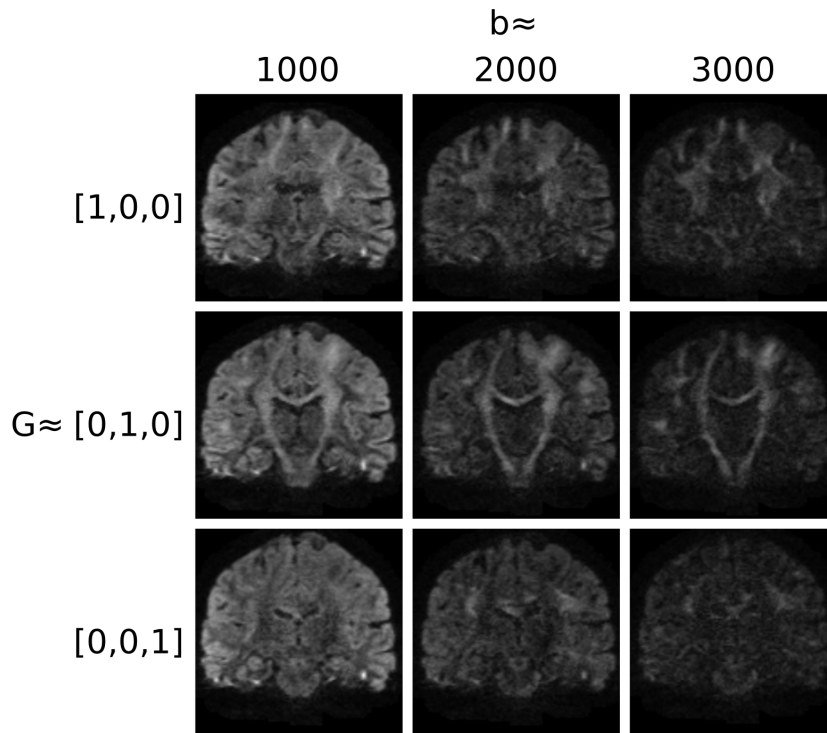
Example of DW-MRI acquired with different b-values ( $b \approx \{1000, 2000, 3000\} \text{s/mm}^2$ ) and gradients  $G$ . Different structures can be appreciated by measuring the diffusion in different directions, while the b-value used changes the contrast in the images.
